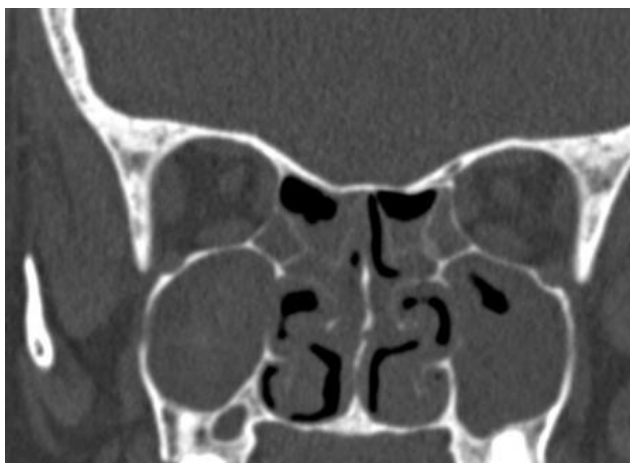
CT PNS coronal section showing heterogenous opacities involving bilateral maxillary sinuses with extension into bilateral ethmoidal sinuses.
